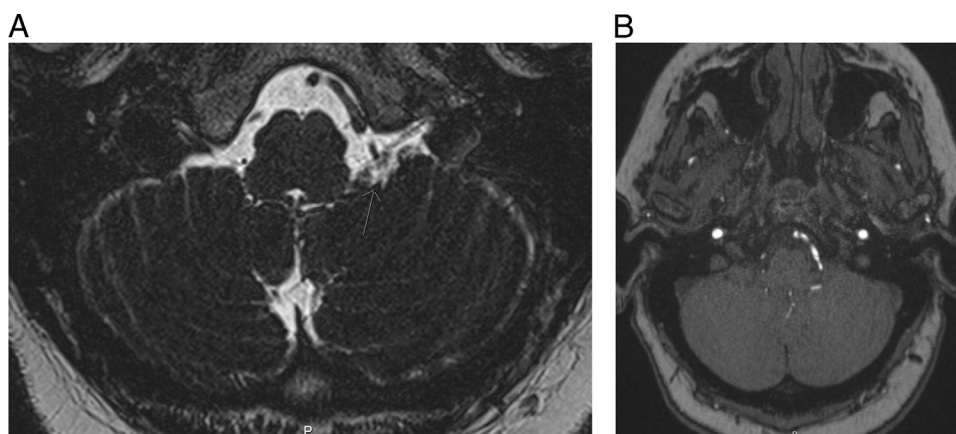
A: MRI axial 3D T2 SPACE: the arrow points to the posterior inferior cerebellar artery that cross the glossopharyngeal nerve closely. B: MRI axial 3D TOF: the hyperintense line next to the brainstem is the thick posterior inferior cerebellar artery. 3D = 3-dimensional; MRI = magnetic resonance imaging; T2 SPACE = Sampling Perfection with Application optimized Contrasts using different flip angle Evolution; TOF =Time of Flight.
